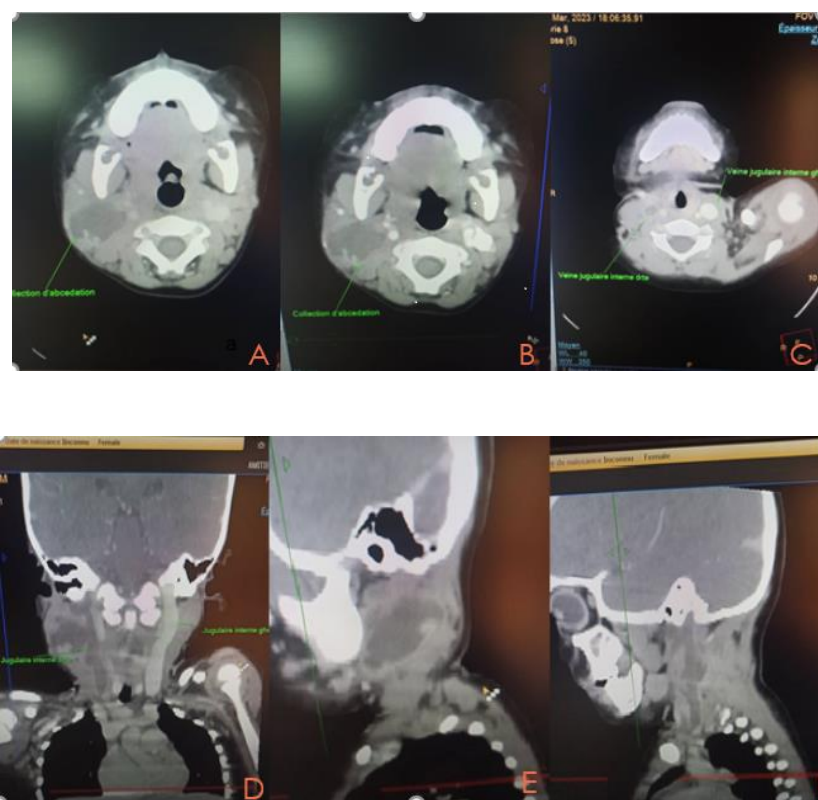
Craniocervical CT in axial sections (A, B, C), coronal (D) and sagittal (E, F) reconstructions highlighting a collection of abscesses in the right subangulo-mandibular region (A, B, D and E) with thrombophlebitis of the right internal jugular vein (C, D and F).
